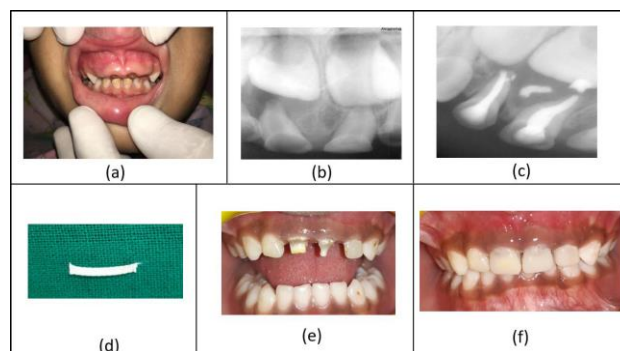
Conventional fibre post as a post and core: (a) preoperative picture; (b) preoperative radiograph; (c) pulpectomy performed w.r.t 61; (d) fibre post preparation; (e) fibre post cementation w.r.t 51; (f) post-operative strip crown restoration w.r.t 61.
